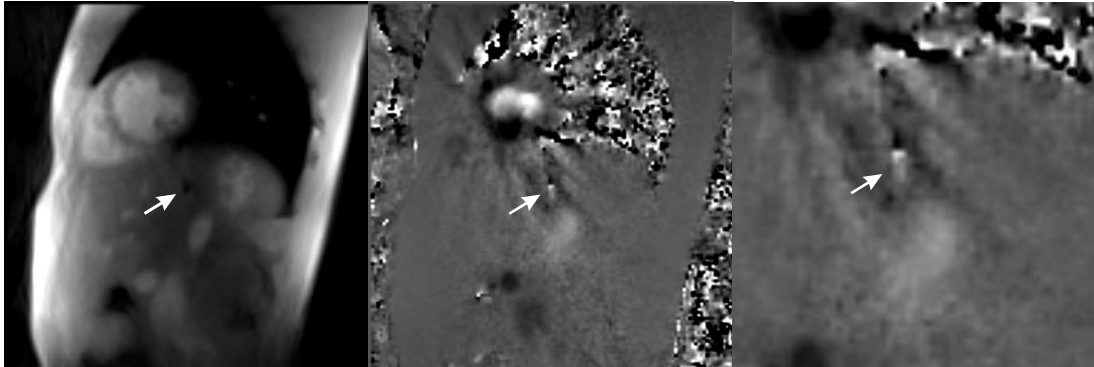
Magnitude image and phase-contrast maps depicting the real-time PC MRI of esophagus at the region of the sphincter. The arrow indicates the passage of bolus through the sphincter muscles in magnitude image and the velocity of bolus flow in phase-contrast map.
